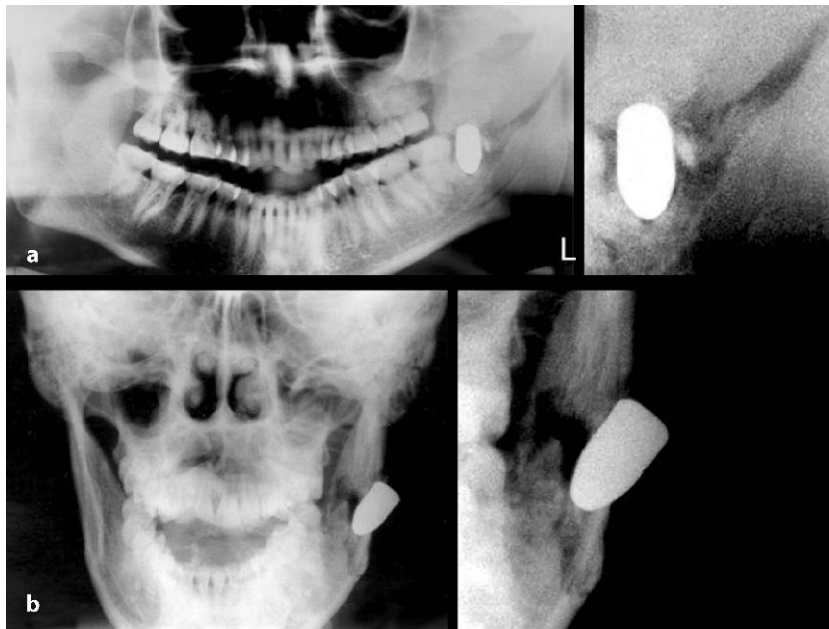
Comminuted fracture of left mandibular ramus caused by gunshot injury. a Panoramic radiograph. b Posterior-anterior radiograph
